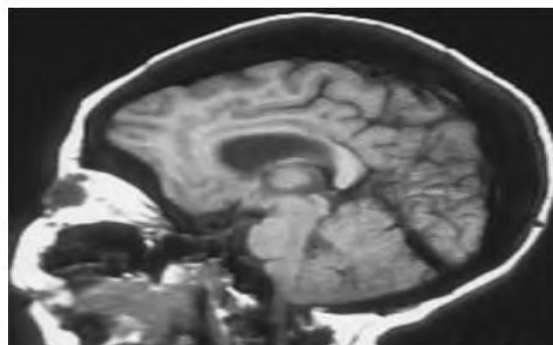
Involvement of skull in osteopetrosis. Thickness in the inner and outer tabulae of calvarial bones, and reduction in the diploic space are seen in this midsagittal SE T1W MR image. Posterior fossa is smaller than normal and foramen magnum is narrowed.
